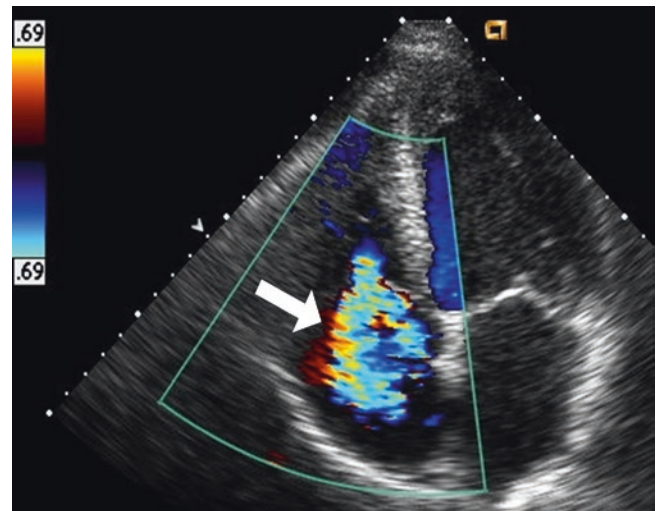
Tricuspid valve assessment using color Doppler. Color Doppler allows gross assessment of the tricuspid regurgitation severity but examination limited to a single view can be misleading. Careful attention must be paid to color Doppler settings such as Nyquist limit and color Doppler gain. In this example, color Doppler examination demonstrates a large jet of tricuspid regurgitation (arrow) consistent with significant tricuspid regurgitation. Spectral Doppler assessment of the tricuspid regurgitant jet can also be performed in this view. Although it can be used to estimate pulmonary artery systolic pressure, interrogation from multiple angles is required for complete assessment which is typically accomplished by comprehensive echocardiography. See also Video 20.9
